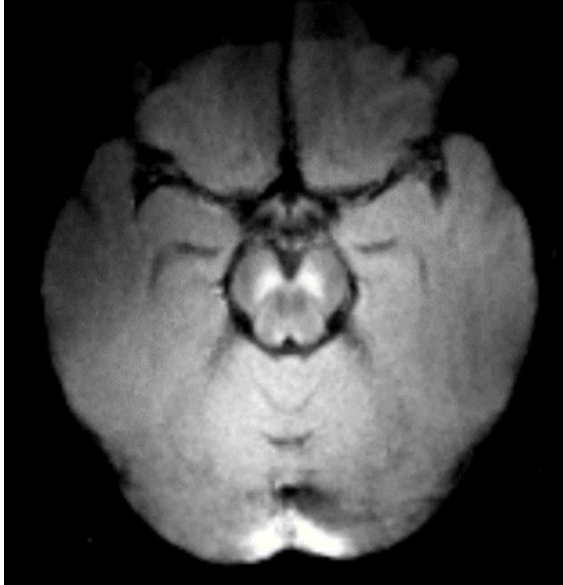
NM-MRI uses NM's paramagnetic properties to create high-contrast images of NM-rich brain regions. The bright area in the midbrain represents the NM-rich SN (Representative participant scan image captured using MRICron at the Royal Ottawa Mental Health Centre).
